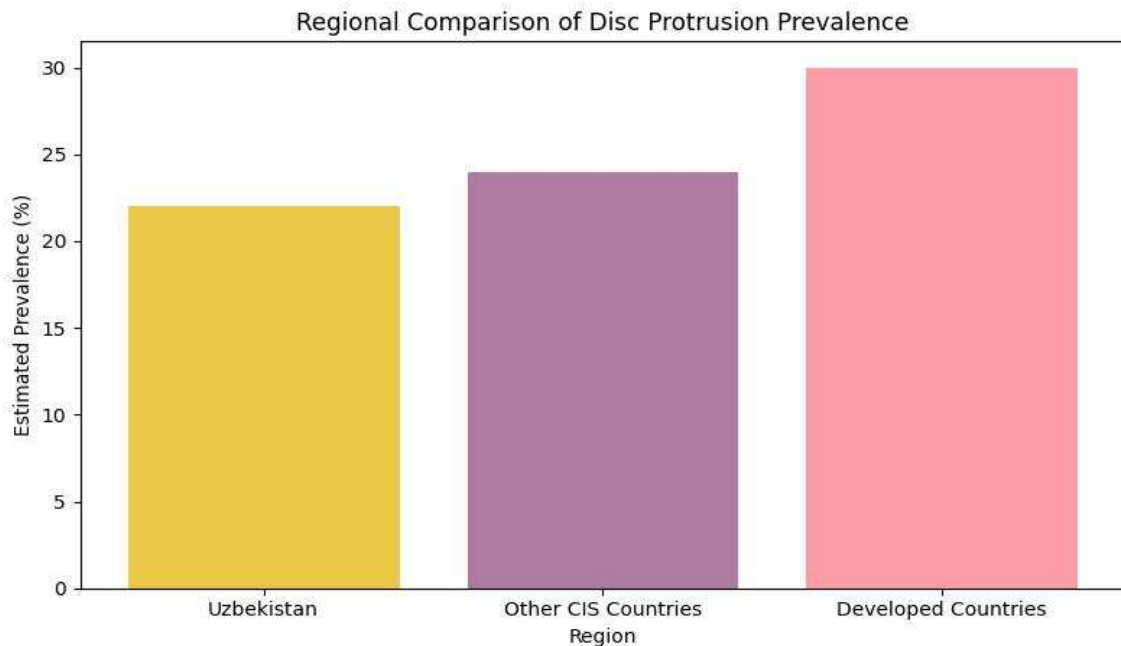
Regional comparison of estimated disc protrusion prevalence. Developed countries demonstrate higher recorded prevalence, largely attributable to broader access to magnetic resonance imaging and early diagnostic screening. Uzbekistan and other CIS countries show slightly lower reported rates, which may reflect underdiagnosis rather than true lower disease burden.
